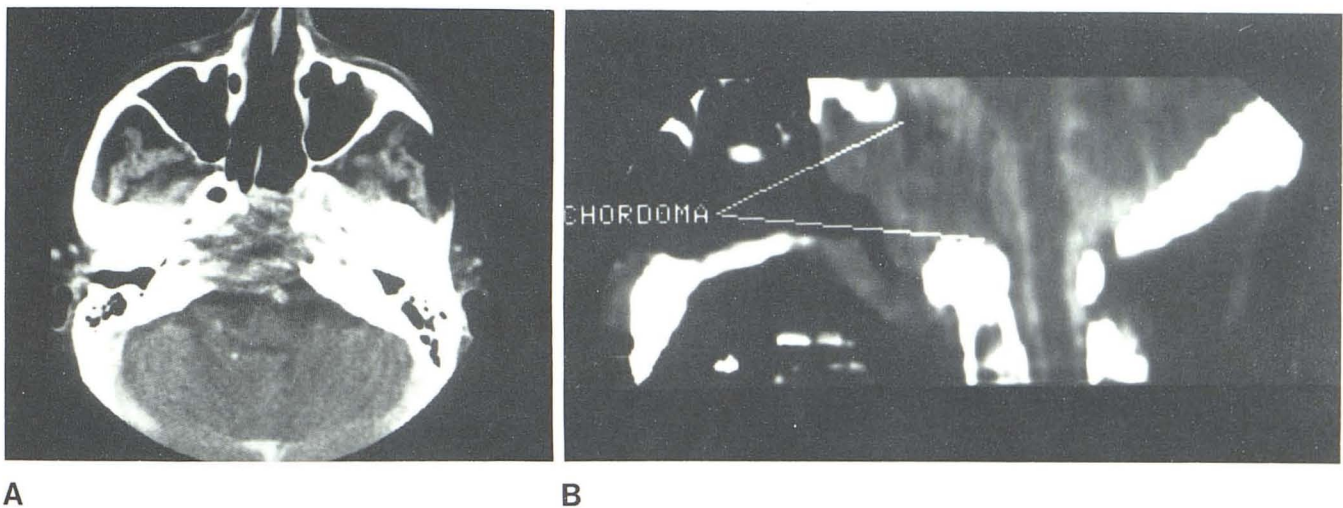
Clivus chordoma. A, Conventional CT. Marked destruction of clivus and sphenoid and suggestion of direct invasion of brainstem. B, Midline sagittal metrizamide study. Neural axis is intact.
